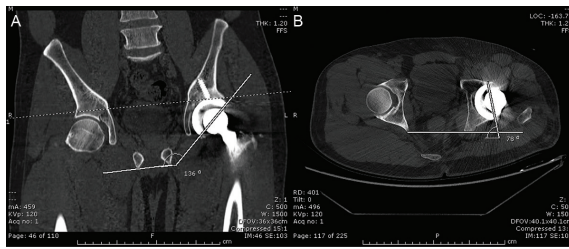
Postoperative CT-scan evaluation of final cup alignment A) abduction and B) anteversion.
